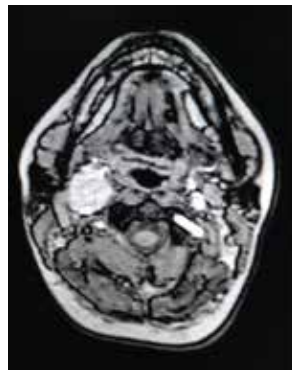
MRI Axial section.
